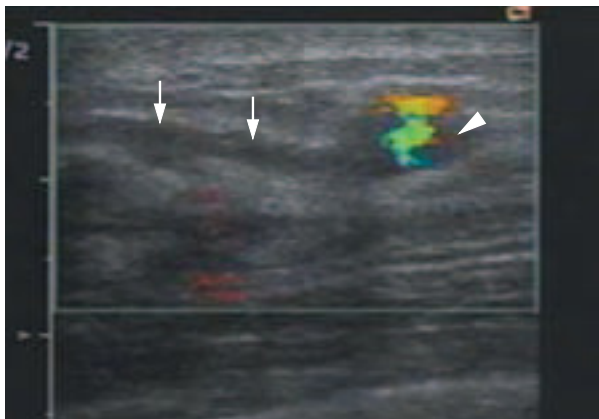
Three-dimensional ultrasound demonstrates a minimally prominent duct (arrow) with a solid tumor (arrowhead) located in the more peripheral portion. Surgical resection of the tumor confirmed the diagnosis of intraductal papilloma.
